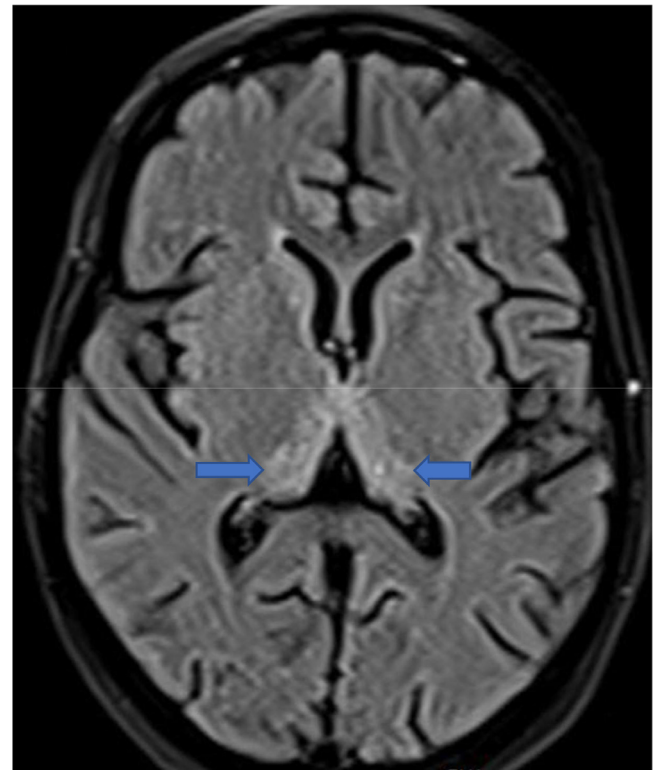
Brain MRI in axial section in T2-weighted sequence showing a bilateral hyper signal of the dorsomedial thalamus (arrows).
